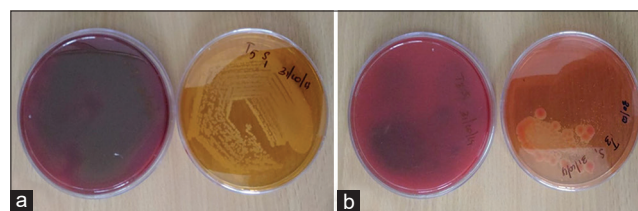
Representative samples with bacterial Growth on blood agar and MacConkey's agar plates in samples from Groups A and B. (a) Group A (side-vented needle irrigation), (b) Group B (passive ultrasonic activation). Marked reductions in bacterial growth were observed in samples from Group B compared to those from Group A
